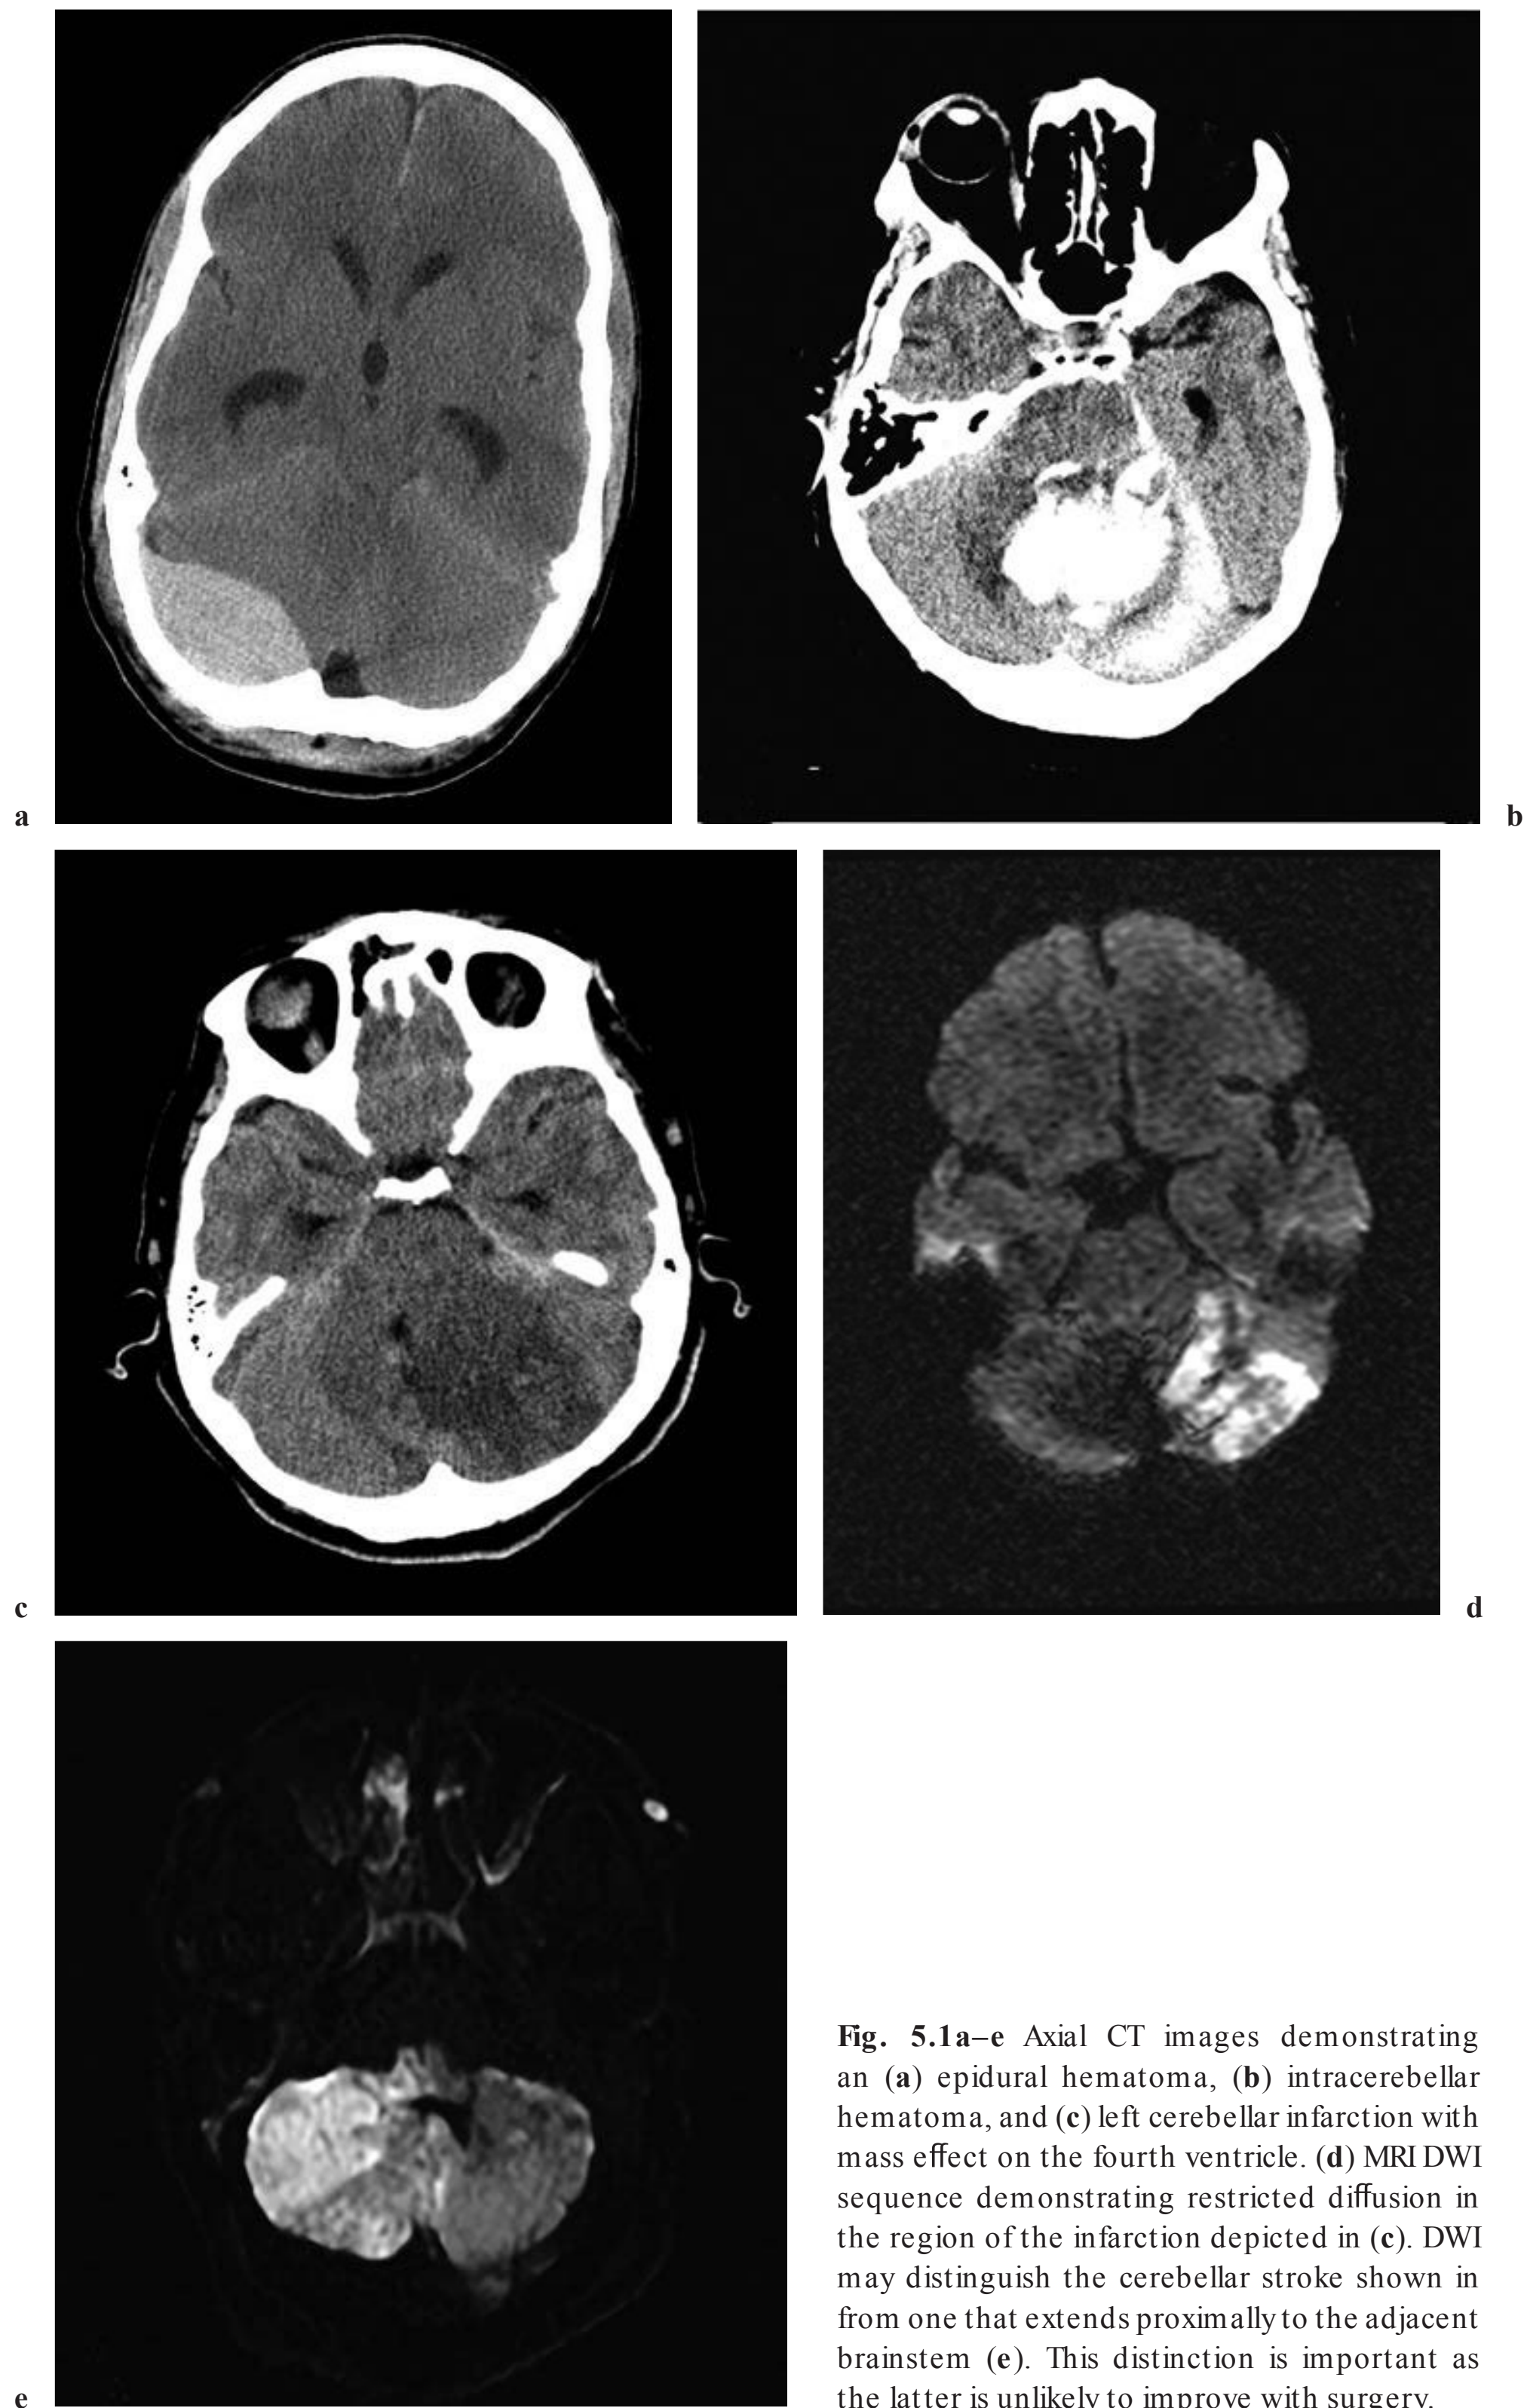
Axial CT images demonstrating an (a) epidural hematoma, (b) intracerebellar hematoma, and (c) left cerebellar infarction with mass effect on the fourth ventricle. (d) MRI DWI sequence demonstrating restricted diffusion in the region of the infarction depicted in (c). DWI may distinguish the cerebellar stroke shown in from one that extends proximally to the adjacent brainstem (e). This distinction is important as the latter is unlikely to improve with surgery.
